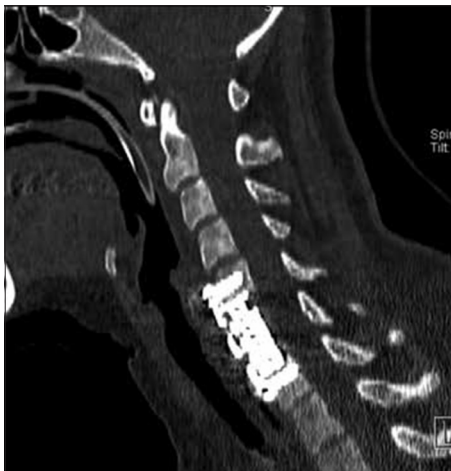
Computed tomography shows C6 corpectomy with C5-C6 and C6-C7 discectomy
